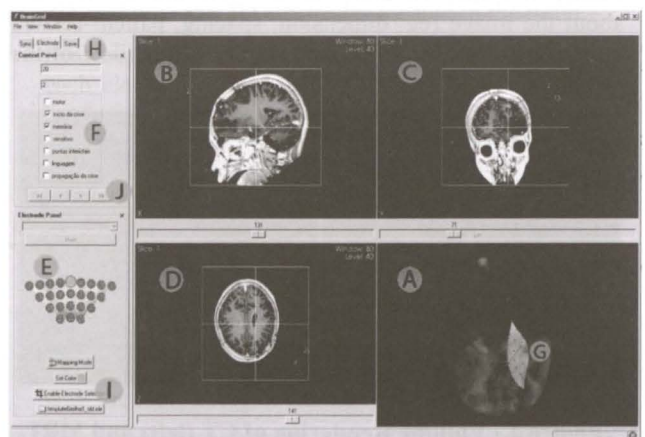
Final Interface, showing MRI, both 2D and 3D, template grid and electrical data in 3D and electrode template grid view.
